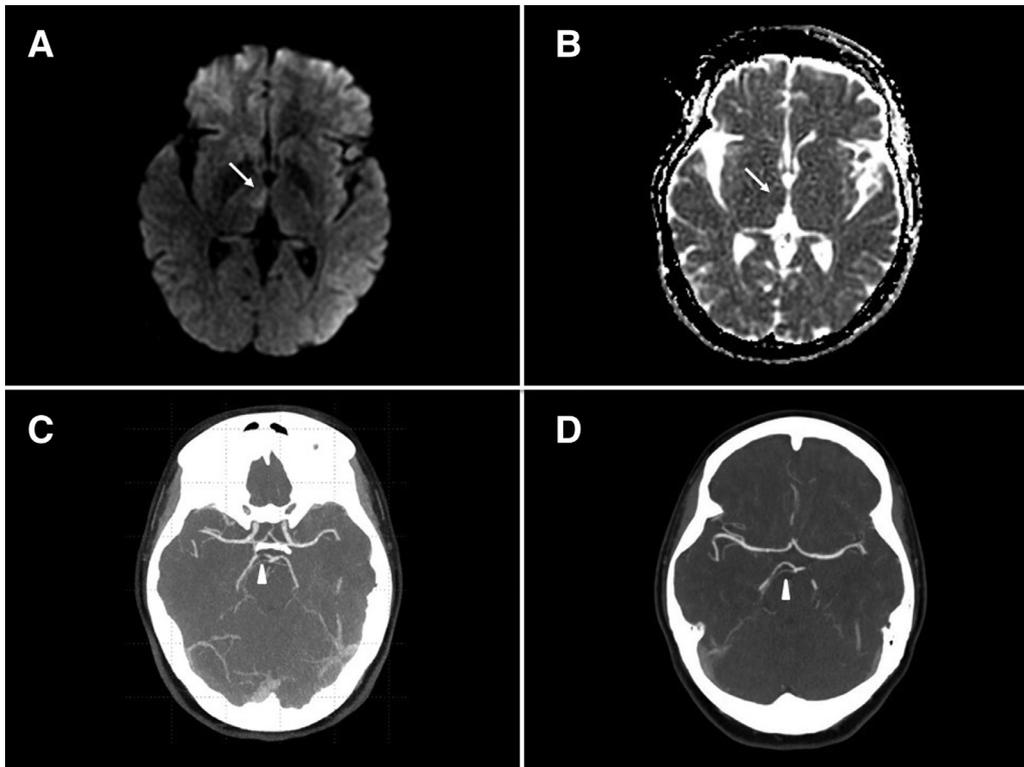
MRI diffusion-weighted (A) and apparent diffusion coefficient (B) images showing acute right medial thalamic infarction (arrows). Initial computed tomography angiography (CTA) (C) shows near occlusion of the right P1 segment of the posterior cerebral artery (arrowhead) with a large right posterior communicating artery. Follow-up CTA 2 months later (D) shows normalization of the right posterior cerebral artery (arrowhead).
